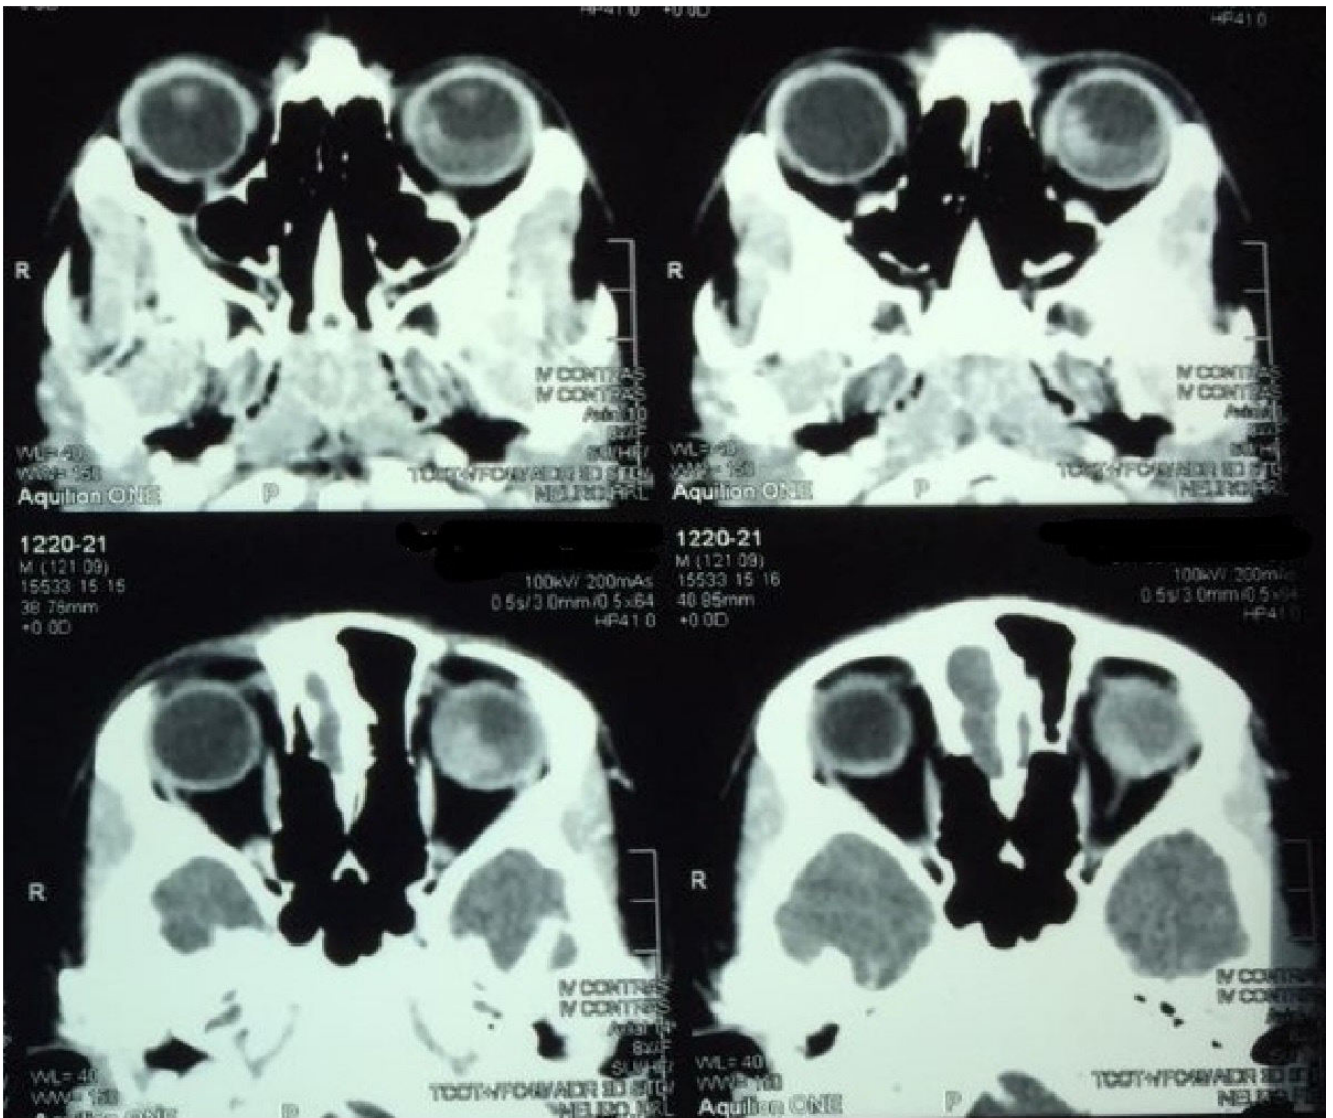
CT scan with contrast (Axial cut) showing intraocular enhancing mass with calcification in the left eye
